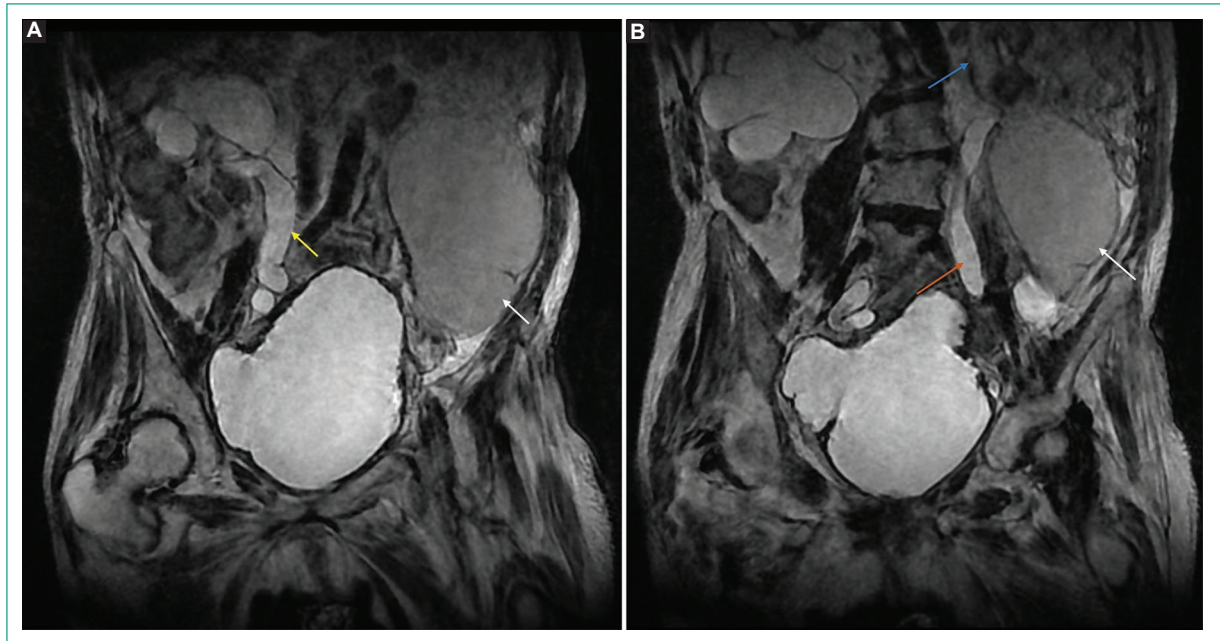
Magnetic resonance imaging, in the coronal plane, demonstrates urinary bladder presenting with diffuse irregular wall thickening, A: right hydronephrosis (yellow arrow) and B: left hydronephrosis (orange arrow). Bilateral loss of corticomedullary differentiation is markedly enlarged on the left kidney (blue arrow) due to a cystic ovarian lesion (white arrow).
